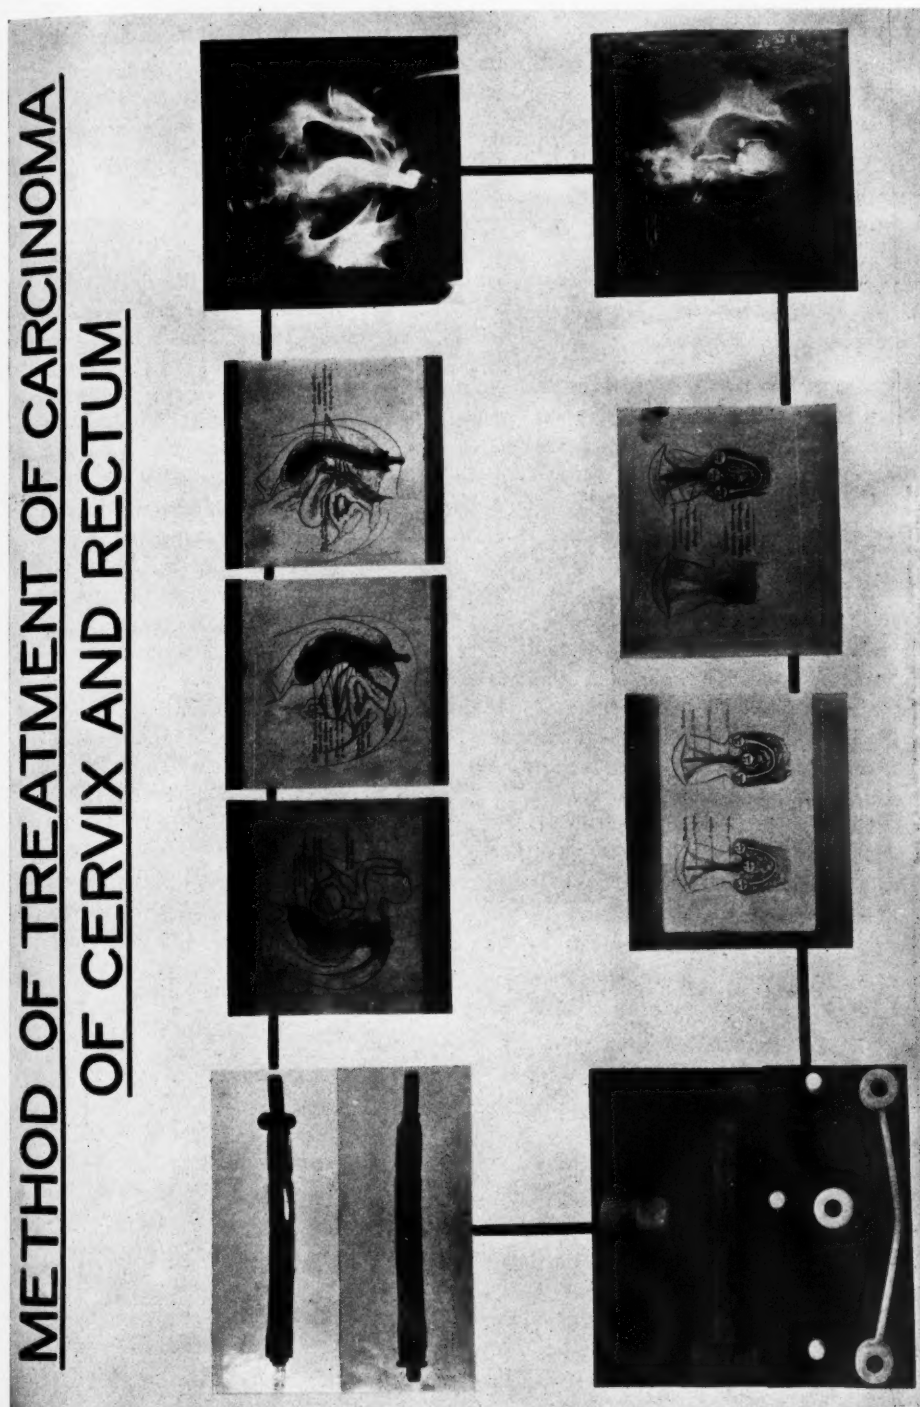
Cancer of the cervix is best treated by irradiation—a combination of high voltage X-rays through the pelvis and an application of radium to the uterus and vagina is the proper procedure. Special applicators, such as the colpostat, have been devised for the convenient application of radium to the cervix. In the treatment of cancer of the rectum, radium plays an important part. A new device for applying heavily filtered radium to the surface of a malignant lesion in the rectum has proven of value in our work.
